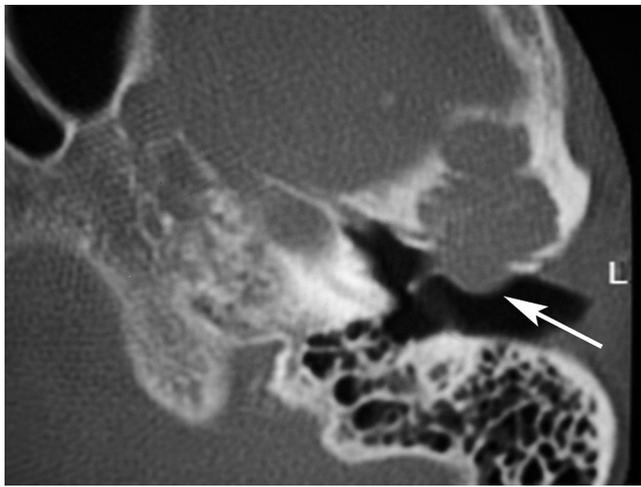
Axial CT shows expansile lesion in the supra-glenoid region with scalloped borders eroding the anterior wall of the bony external auditory canal.
